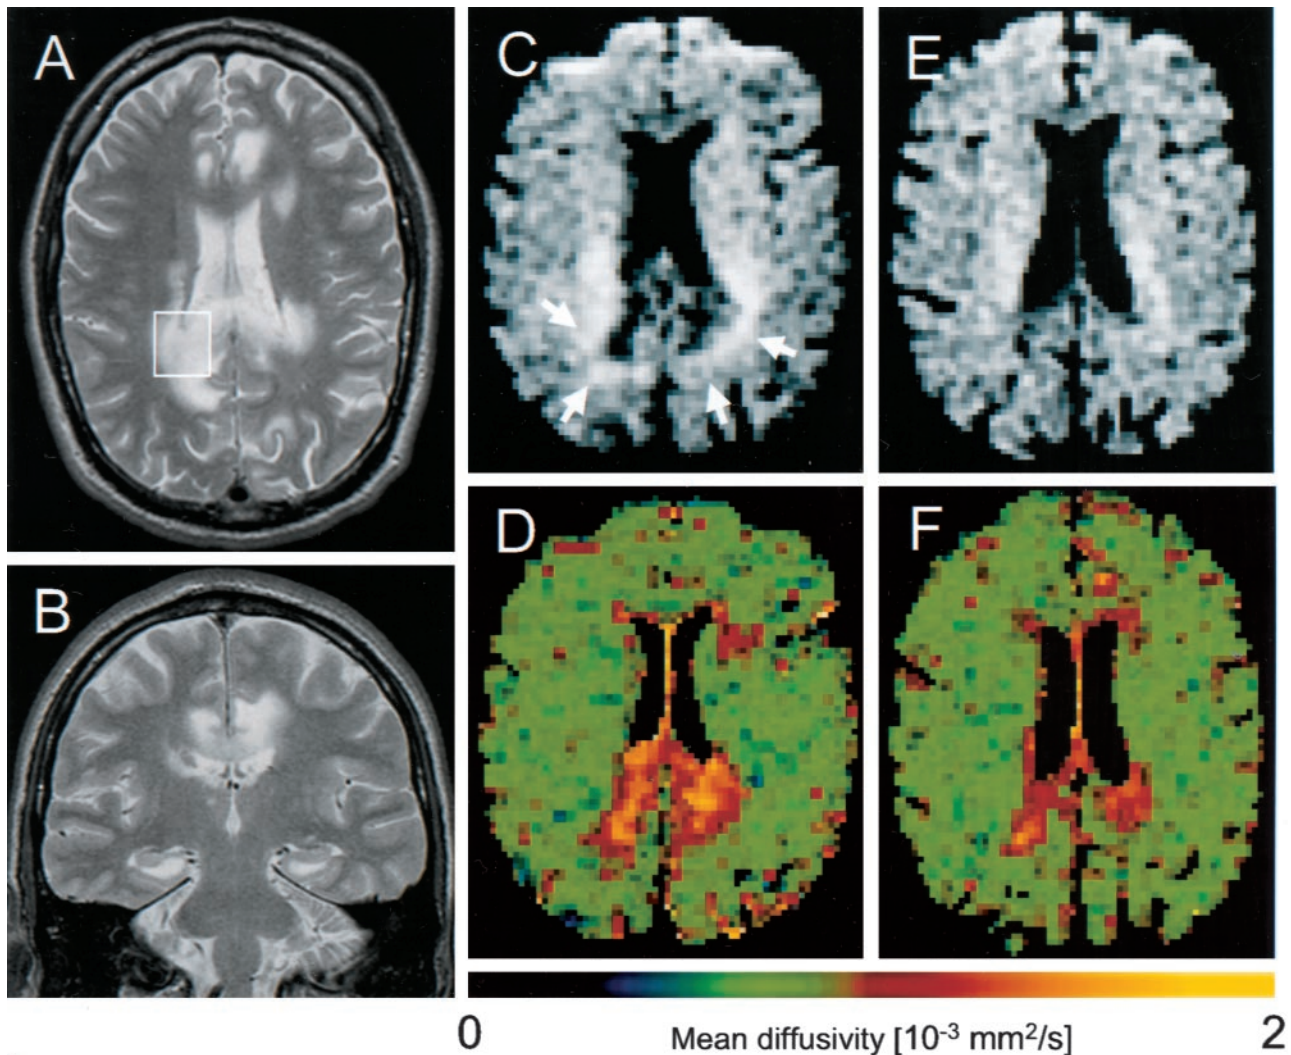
A and B, Axial and coronal T2-weighted images (1.5 T, TR/TE = 3800/84 and 3500/75, respectively) show extensive areas of abnormally high signal intensity in the splenium and the perisplenial, cingulate, and the bilateral perisplenial white matter. Note sparing of the hippocampi and the temporal and insular cortices. C–F, Diffusion-weighted images (upper row [C and E]) and corresponding apparent diffusion coefficient false-color maps (lower row) of week 8 (D) and week 26 (F) after disease onset. Note that the CSF signal intensity is nulled. C and D, Lesions on diffusion-weighted images 4 weeks after the first MR study (C) show hypointense central area with a hyperintense rim (arrows) and high regional mean diffusivity. E and F, Note resolution of diffusion-weighted hyperintensities and peripheral normalization of regional mean diffusivity, indicating irreversible necrosis and gliosis formation in areas with regional mean diffusivity exceeding about $1.4 \times 10^{-3} \text{ mm}^2/\text{s}$, whereas initially hyperintense areas on diffusion-weighted images, mainly representing T2 shine-through, without corresponding reduction of regional mean diffusivity reflect potentially reversible inflammatory changes. (Image acquisition: TR/TE = 2200/120, tetrahedral gradient acquisition scheme [15] with b values of 330, 798, and 1320 s/mm^2)
